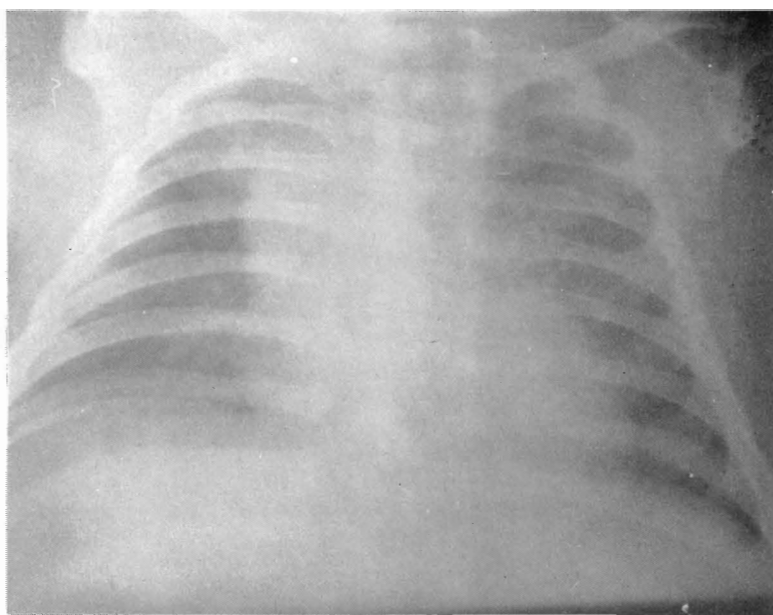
Chest X-ray findings
